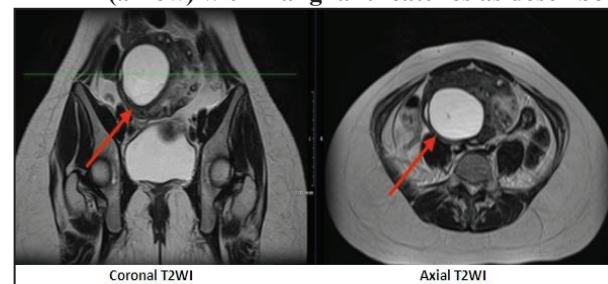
MRI pelvis images showing left ovarian torsion (arrow)
